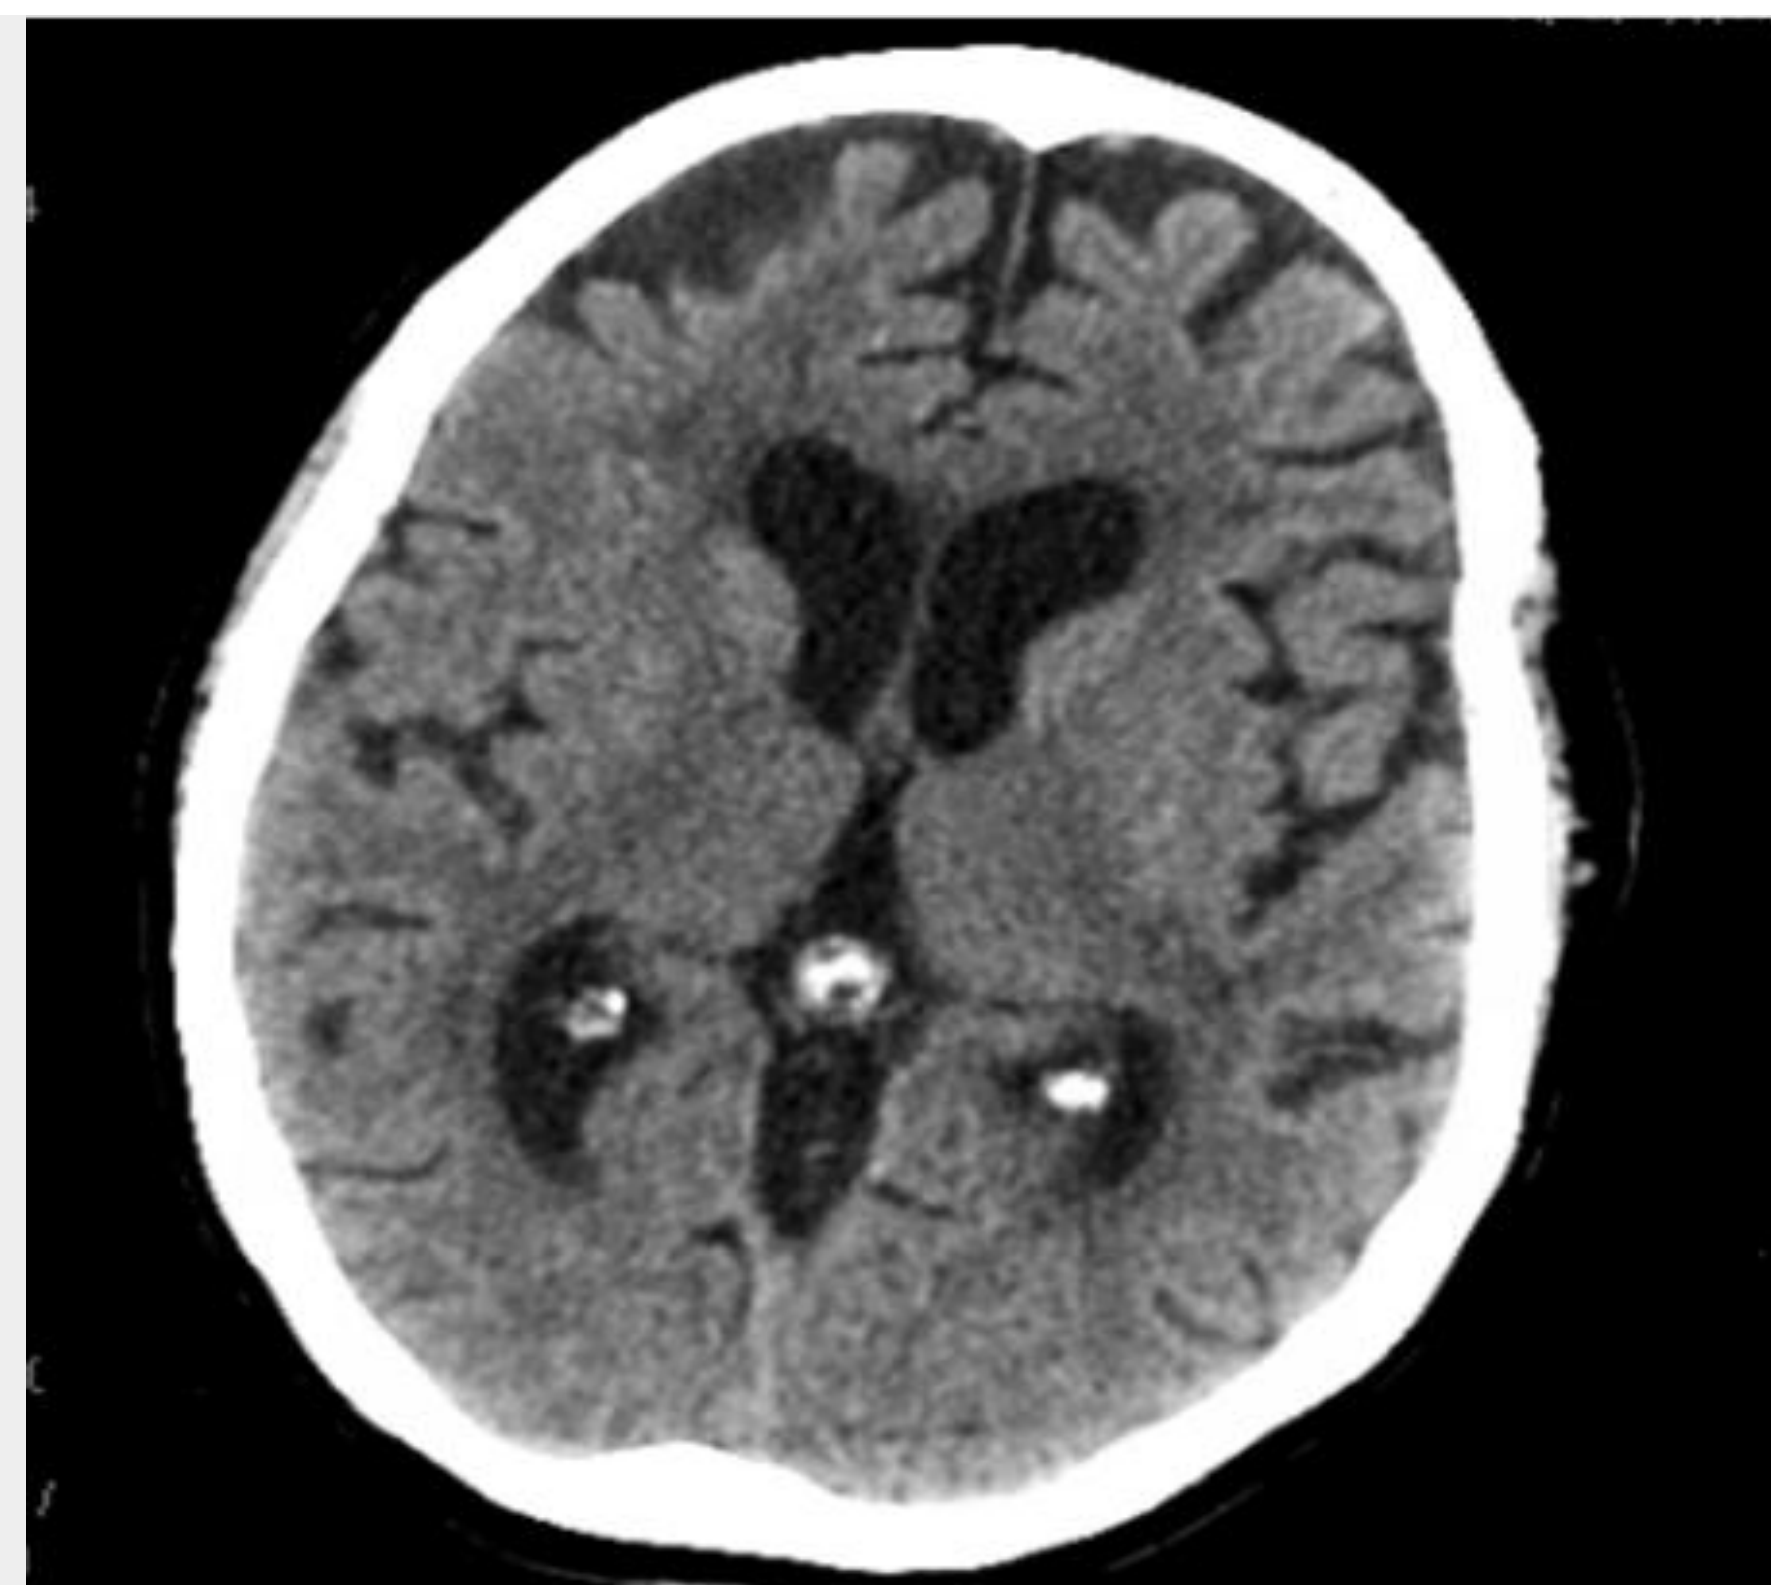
CT head without contrast
